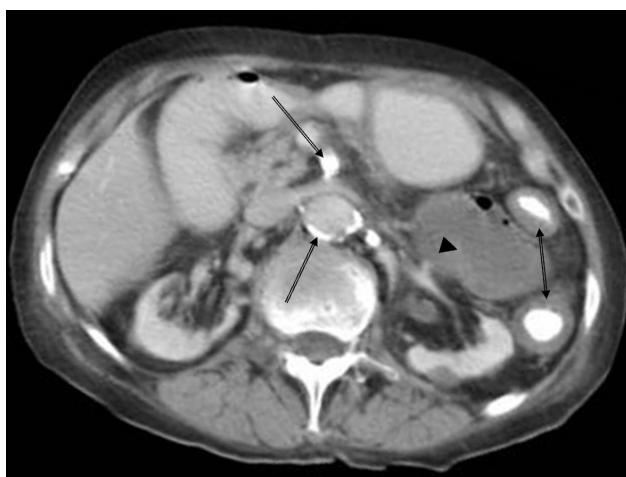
Abdominal CT examination: Diffuse concentric thickening observed in the descending colonic wall. Contrast filling cannot be seen in the wall (double head arrow). Intestinal distention with fluid observed nearby (arrow head). Calcified plaques in abdominal aorta and SMA are visualized (arrow).
